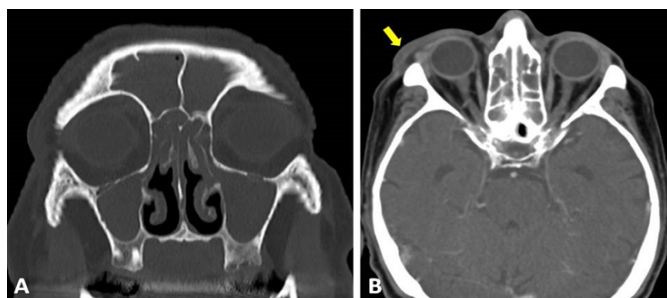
Cranial CT scan with contrast- Image A (Bone window, oblique reconstruction) showed heterogeneous filling of all anterior paranasal sinuses, that suggested acute pansinusitis. Image B (axial plane, after contrast enhancement) showed edematous densification of the right periorbital soft tissues (arrow) and swelling-right periorbital edema.
